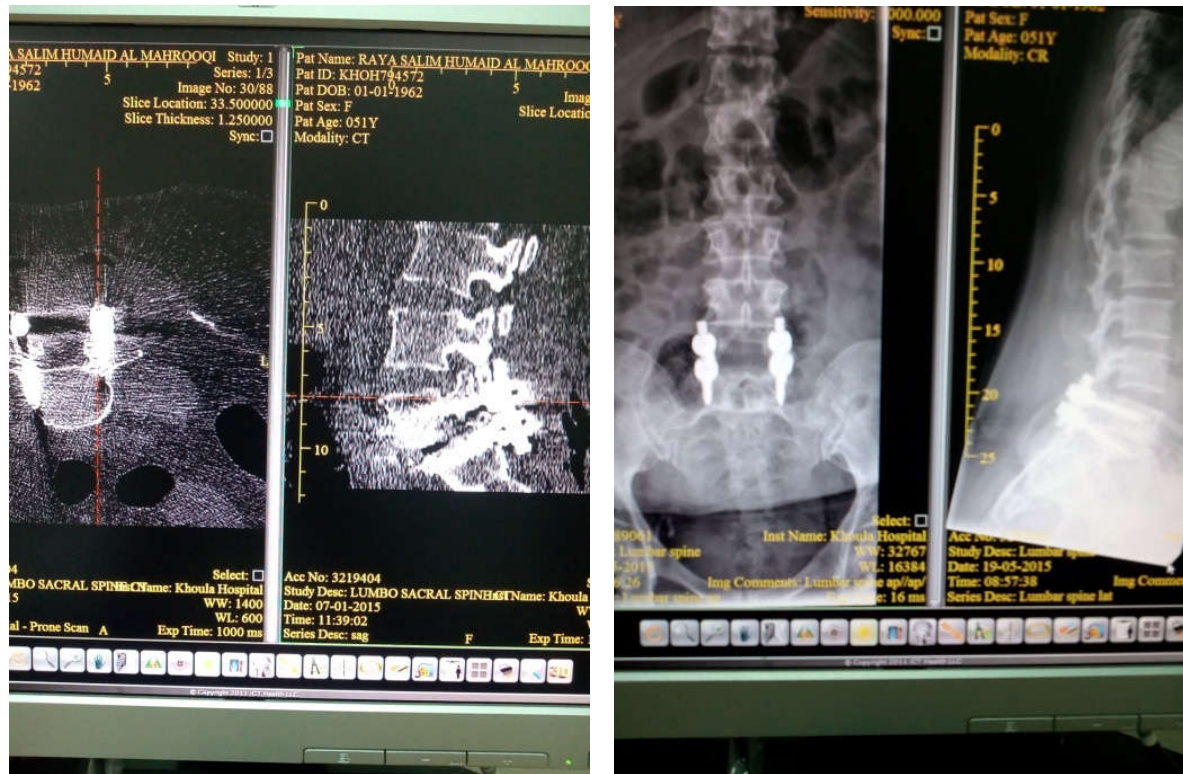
Use of intraop CT in PLF
